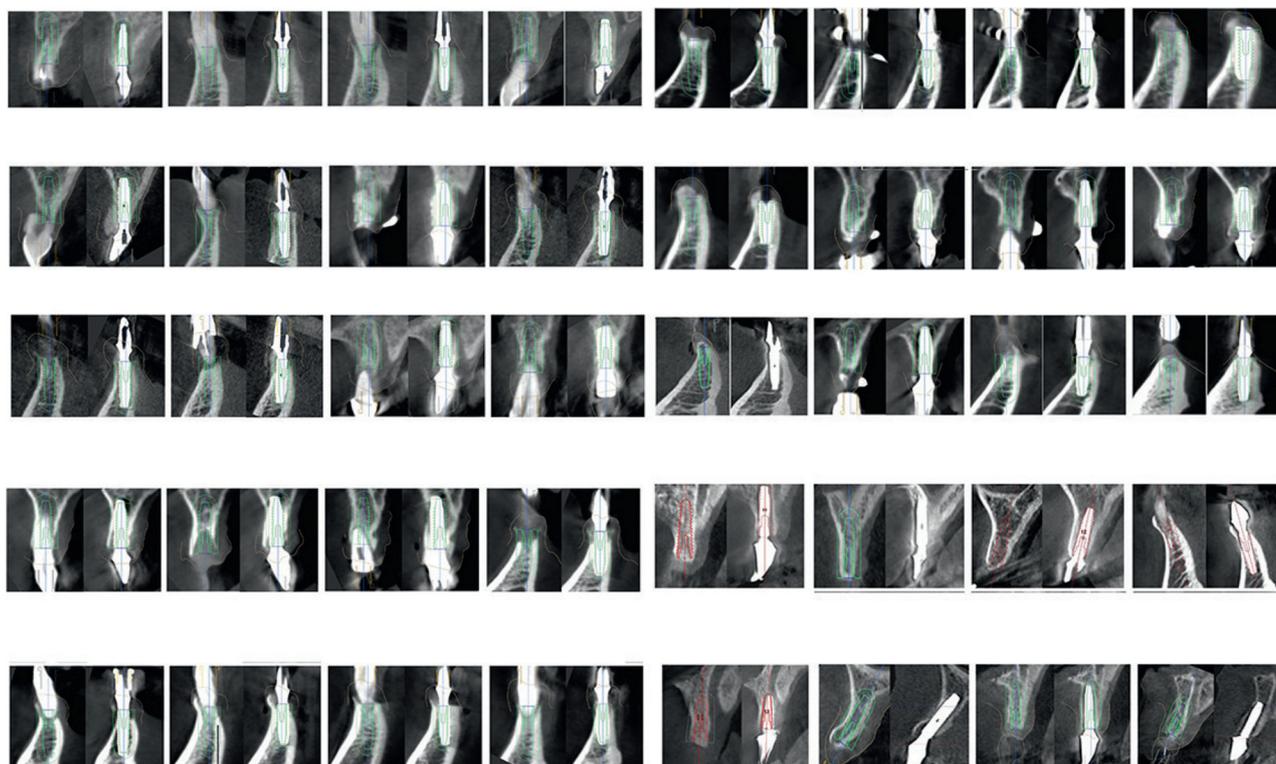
Cone beam computed tomography (CBCT) scans obtained before and after surgery from 32 participants.
